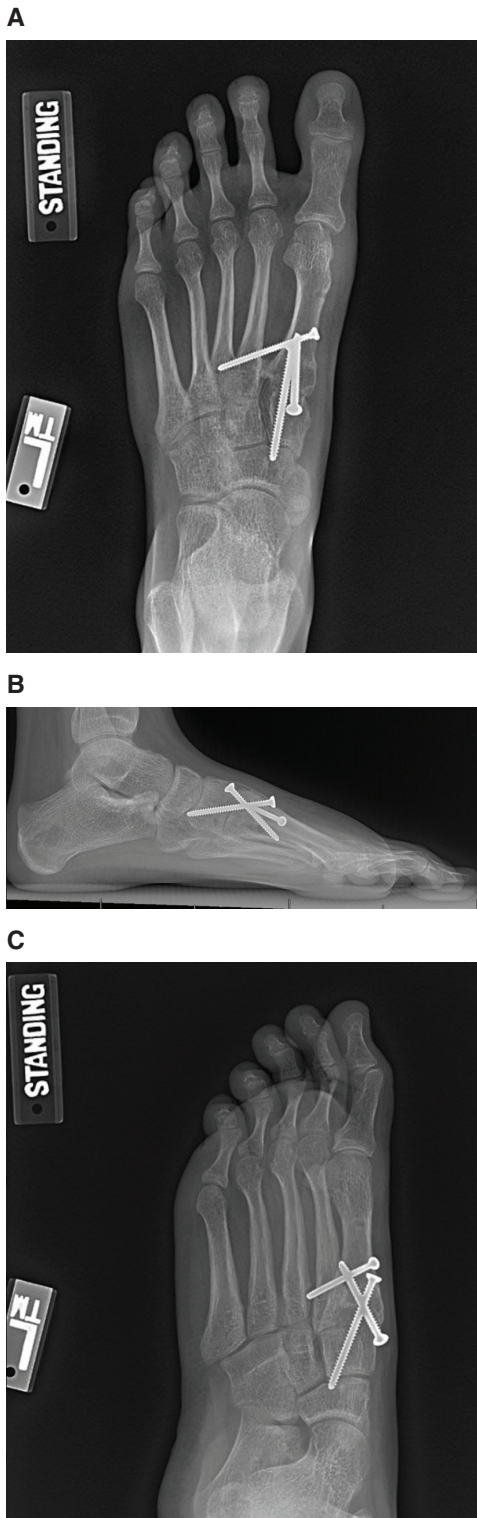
Six-week postoperative AP (A), lateral (B), and oblique (C) radiographs of patient from Figure 1 demonstrating successfully maintained correction of hallux valgus.
